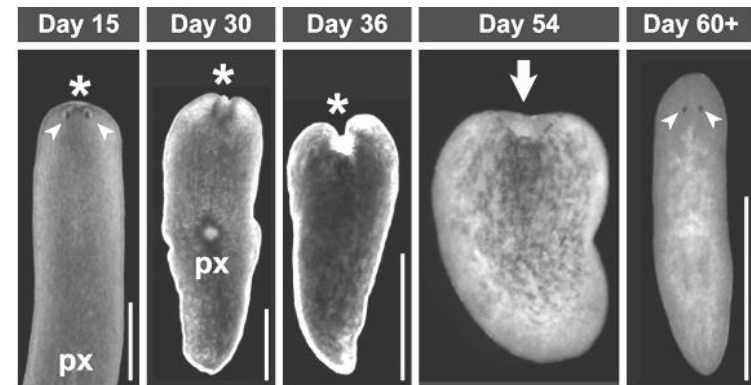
Planarian exposed to a lethal dose of X-rays on days 15, 30, 36, 54, and after day 60. The asterisk marks the head end where the most intense tissue death begins, the arrow marks the blastema formed by regeneration of the lost body part, and the triangular arrows mark the eyes
